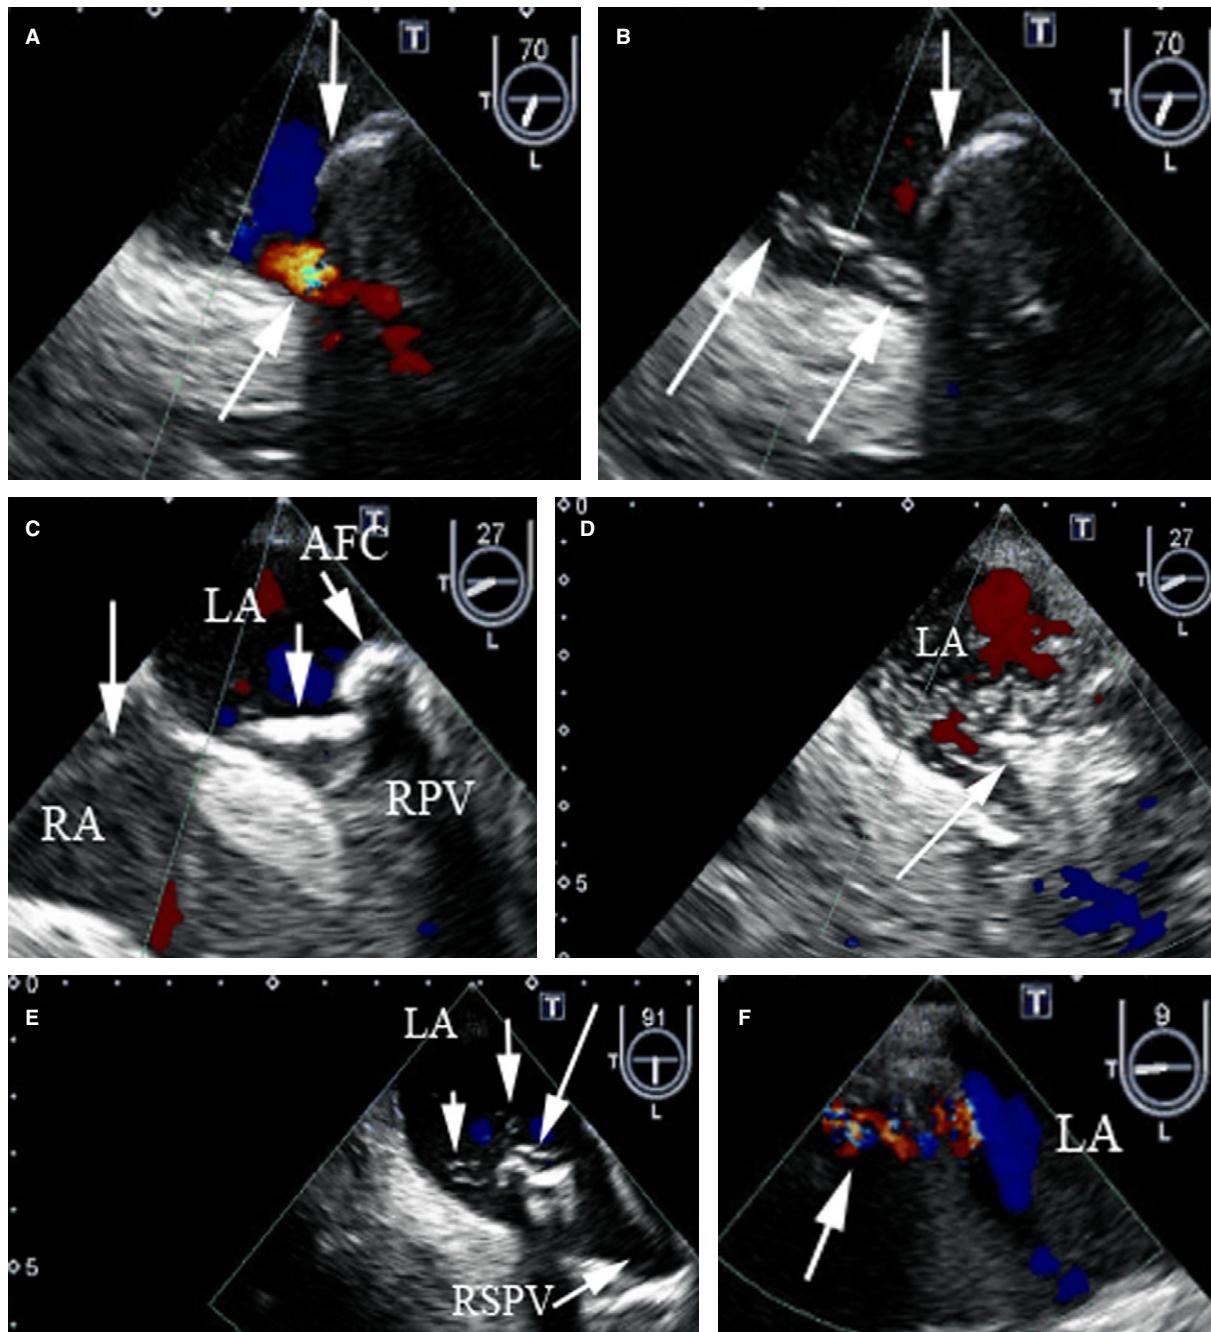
A–F. Sequence of cryoballoon ablation (CBA) within the RPVs. The (A) RUPV is incompletely sealed (oblique arrow) by the AFC (vertical arrow), but the CBA procedure performed. What appears to be (B) ice (oblique arrows) is noted to stream from the area of incomplete AFC-PV closure. Within 30 seconds of initiating CBA (C) the AFC-PV seal is complete. At this TEE angle (27°) the catheter (vertical arrows) is visualized across the IAS and the inflated AFC (oblique arrow) well visualized. As the (D) AFC is deflated (arrow) there is initially a large amount of presumptive ice noted within the LA. Upon (E) slight pullback of the AFC (oblique arrow) presumptive ice is noted (vertical arrows) emanating from the surface of the AFC. During the CBA procedure, when the AFC balloon is (F) inflated the refrigerant N₂O is noted by TEE as a color mosaic pattern (arrow) within the balloon. IAS = interatrial septal; TEE = transesophageal echocardiography.
